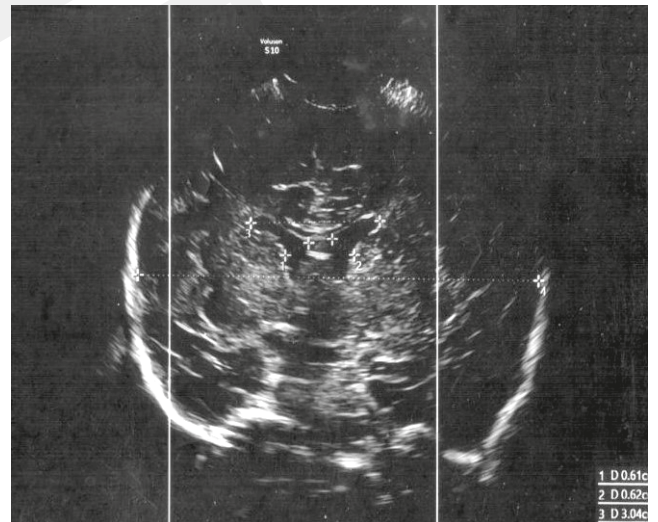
Central nervous system ultrasonography -14th day of life. Increased echogenicity and features of thickening of soft dura and arachnoid, increased furrows echogenicity, slight blurring of boundaries between bends and furrows. Low quality photo – scan of videoprinter printout
